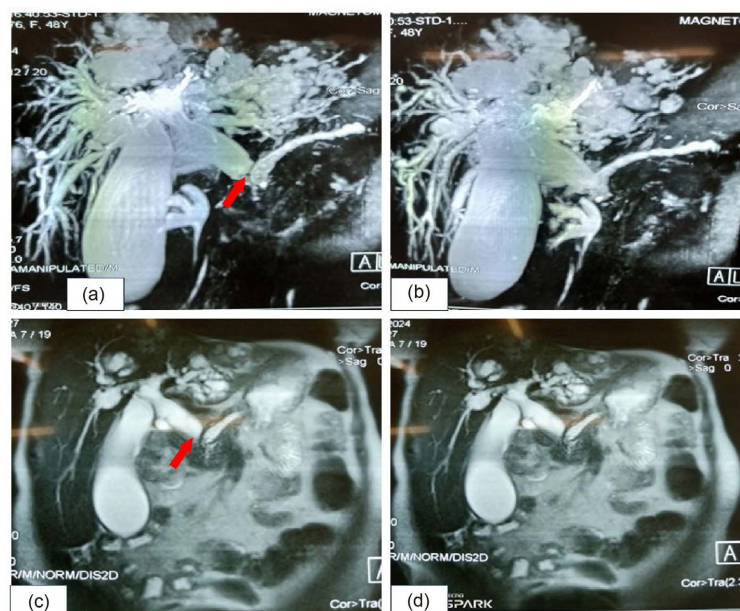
Bili-MRI showing a tissue mass of the biliodigestive junction responsible for a significant dilation of the intra- and extra-hepatic bile ducts and a moderate dilation of the main pancreatic duct suggestive of a Vater's ampulloma (patient number 1).
